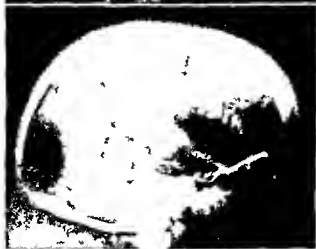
X-Ray Films of Skull Showing Increase of Bone Density in Hyperparathyroidism as a Result of High Calcium Diet
